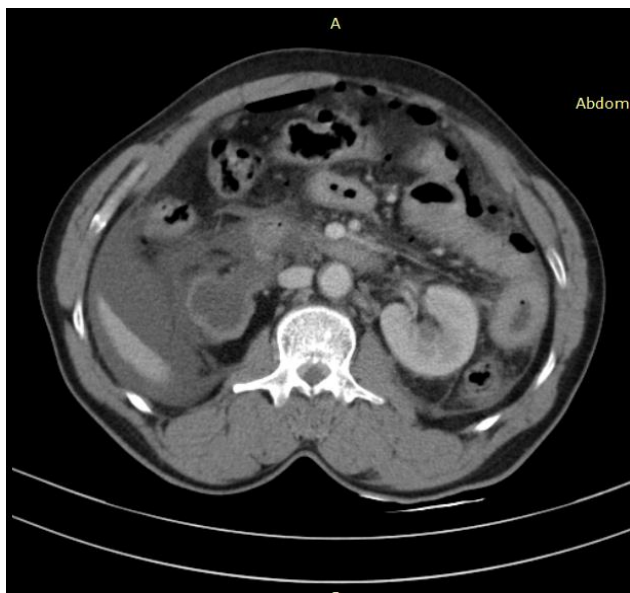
Axial CT post contrast image at the level of upper pole of kidneys showing normally enhancing left kidney and a decompressed dilated pelvicalyceal system of the upper moiety of right kidney with parenchymal thinning and dehiscent pelvic outline in the anteromedial aspect with urinary ascites. In addition perforation of the second part of duodenum with pneumoperitoneum was noted.
